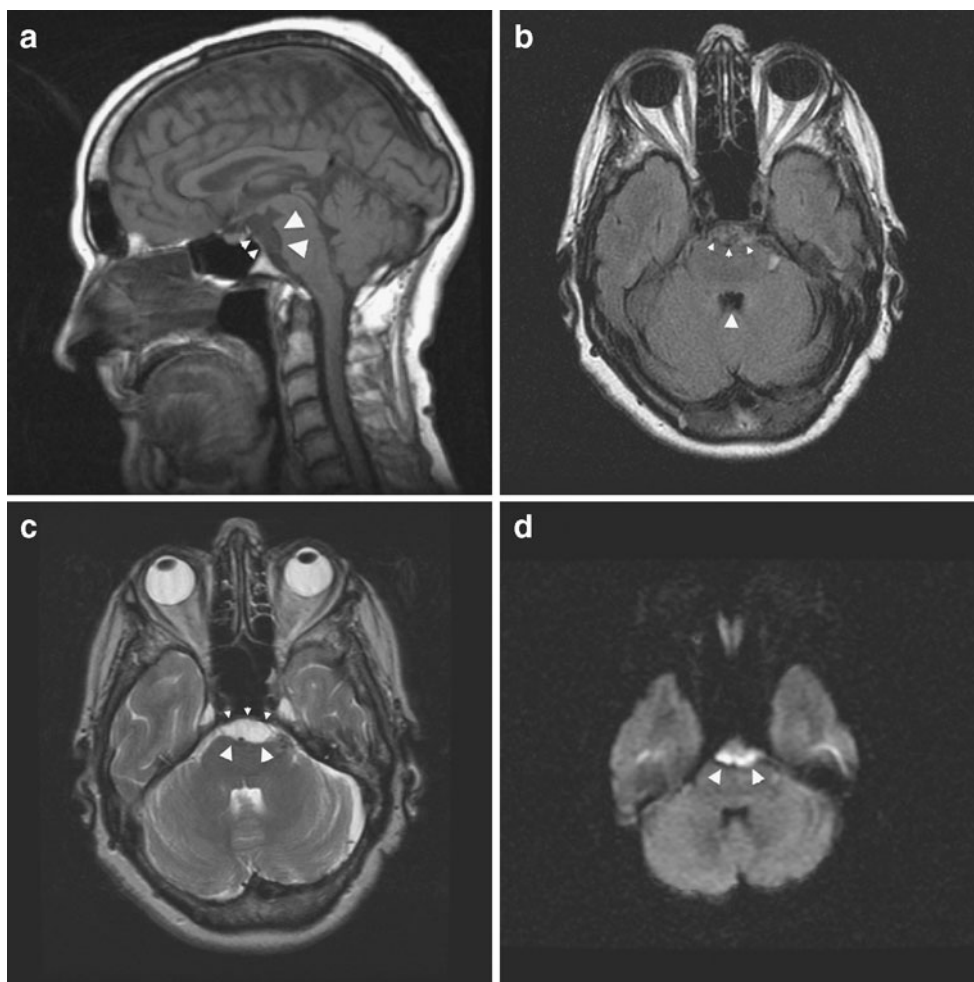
A 72-year-old male presenting with headache. a Sagittal 3-mm-thick SE T1-weighted image. A slightly inhomogeneous mass lesion is seen in the prepontine cistern (*small arrowheads*) with compression on the brain stem (*large arrowheads*). The linear flow void situated just anterior to the brain stem is the compressed basilar artery. b Axial 3-mm-thick FLAIR image through the posterior fossa. The mass lesion demonstrates an inhomogeneous appearance (*small arrowheads*). Compare with the homogeneous hypointense appearance of the CSF in the fourth ventricle (*large arrowhead*). c Axial 3-mm-thick TSE T2-weighted image through the posterior fossa. The mass lesion has a homogeneous high signal intensity (*small arrow-*
